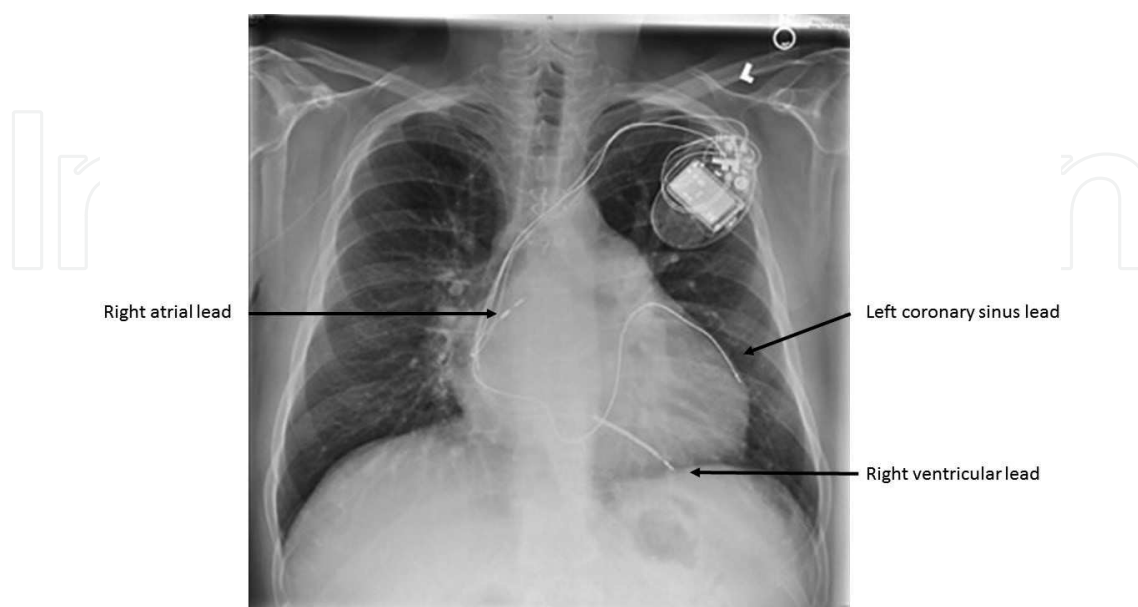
A chest X-ray after a successful CRT implantation.
